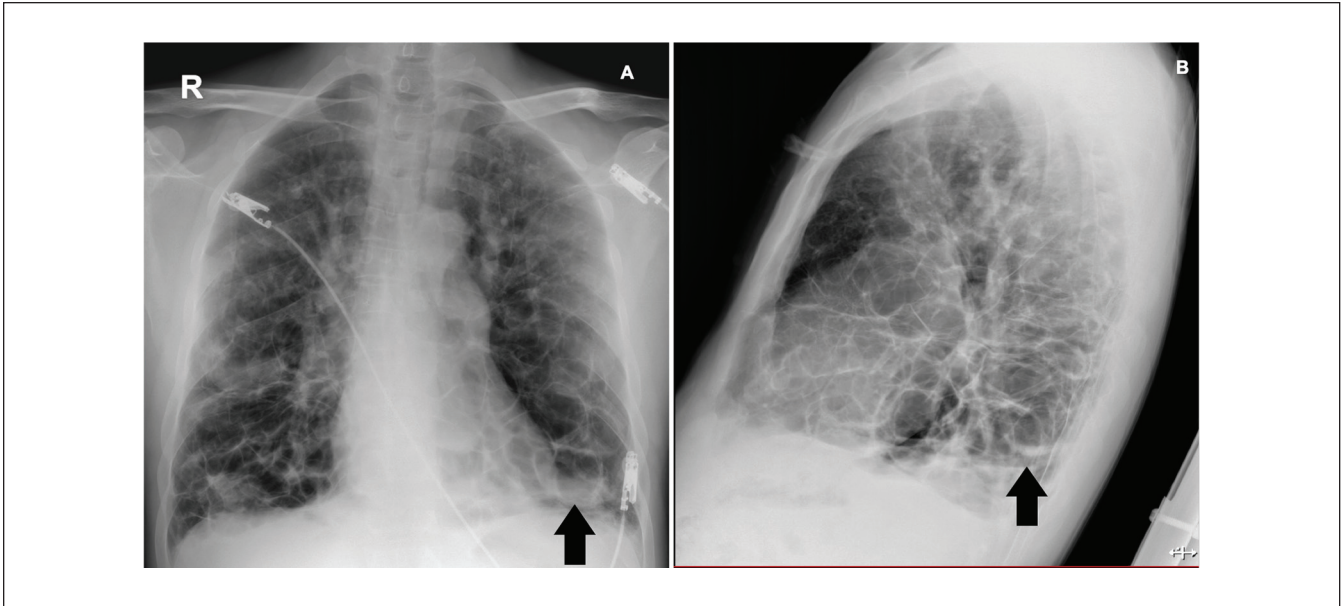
(A and B) Anteroposterior and lateral chest X-ray. Central trachea and cystic images with thin walls less than 4 cm in the lower two thirds of both lungs, some with presence of air fluid level (black arrow).
